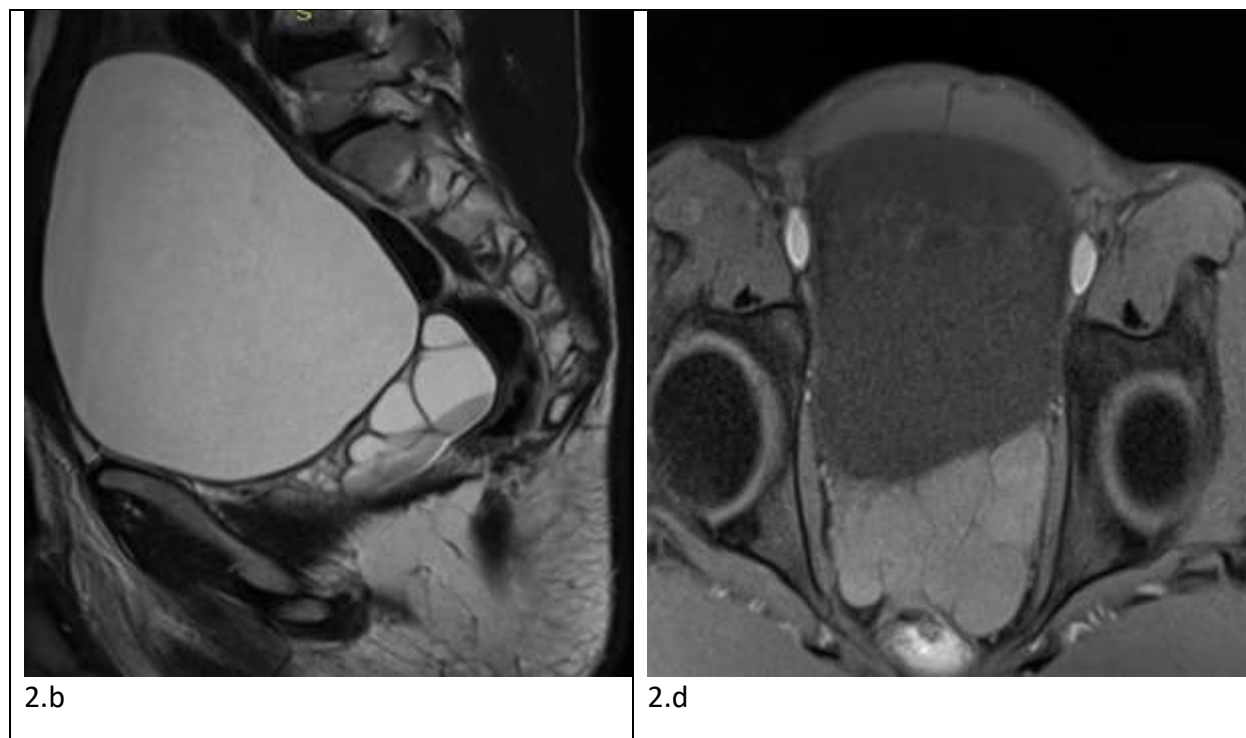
(a) MRI T2-W image revealing left renal agenesis; and s coronal (a) and T2-W and T1-W images in sagittal and axial planes revealing large ipsilateral left seminal vesicle cyst.
